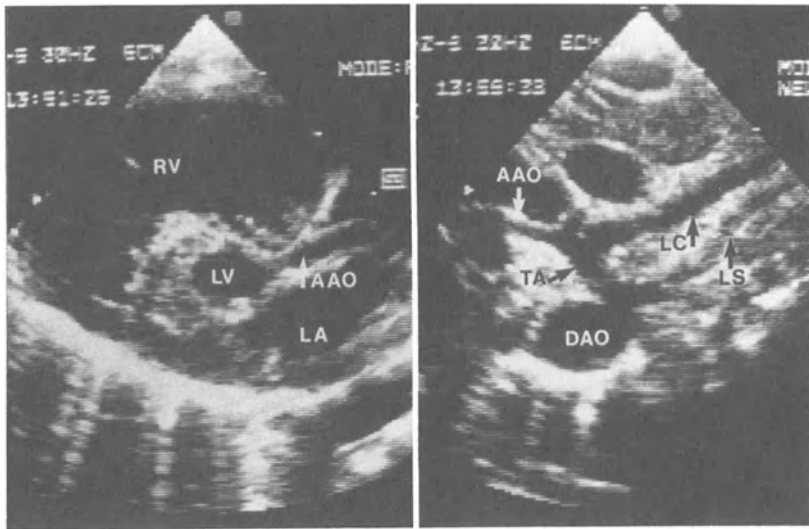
Two-dimensional echocardiograms showing the hypoplastic left ventricle (LV) and ascending aorta (AAO). The transverse aortic arch (TA), left carotid (LC), and left subclavian (LS) arteries and descending aorta (DAO) are well seen. (LA, left atrium; RV, right ventricle.)
